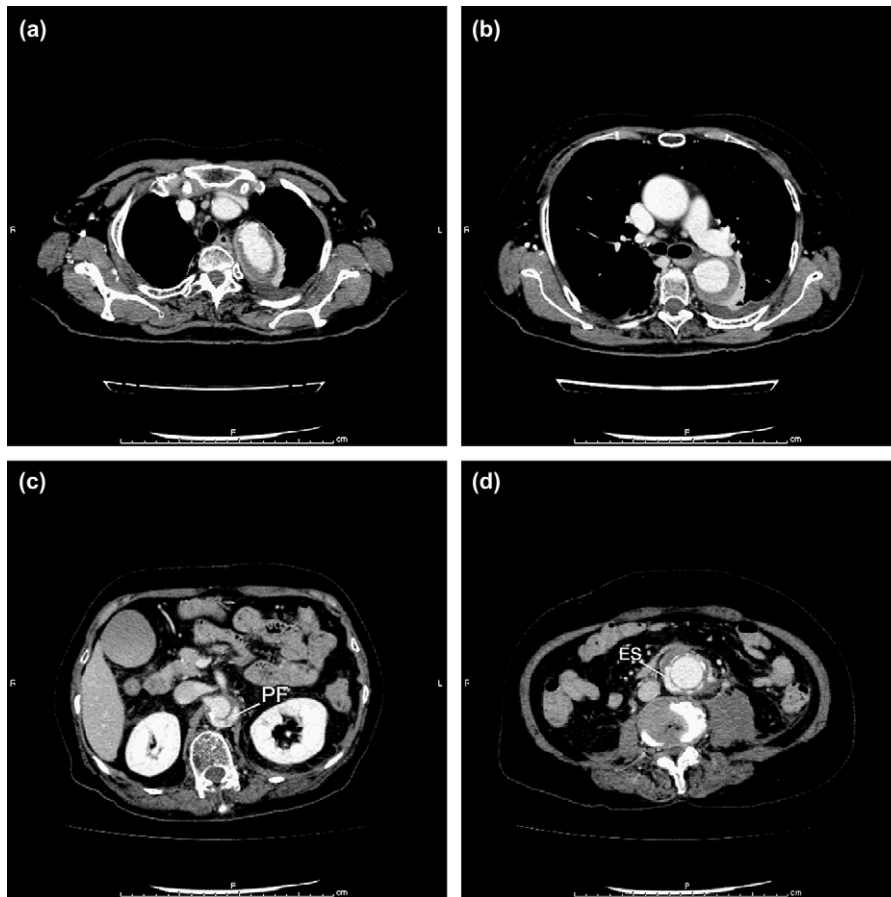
(a) Computed tomograph on day 6 at the distal arch level. Still no ULP. (b) Computed tomograph on day 6 at the carina level with no ULP. (c) Computed tomography on day 6 at the right renal artery level showing patent false lumen (PF). (d) Computed tomography on day 6 around the previous suture line showing the encased hematoma around the graft, part of which is enhanced by contrast medium (ES).
